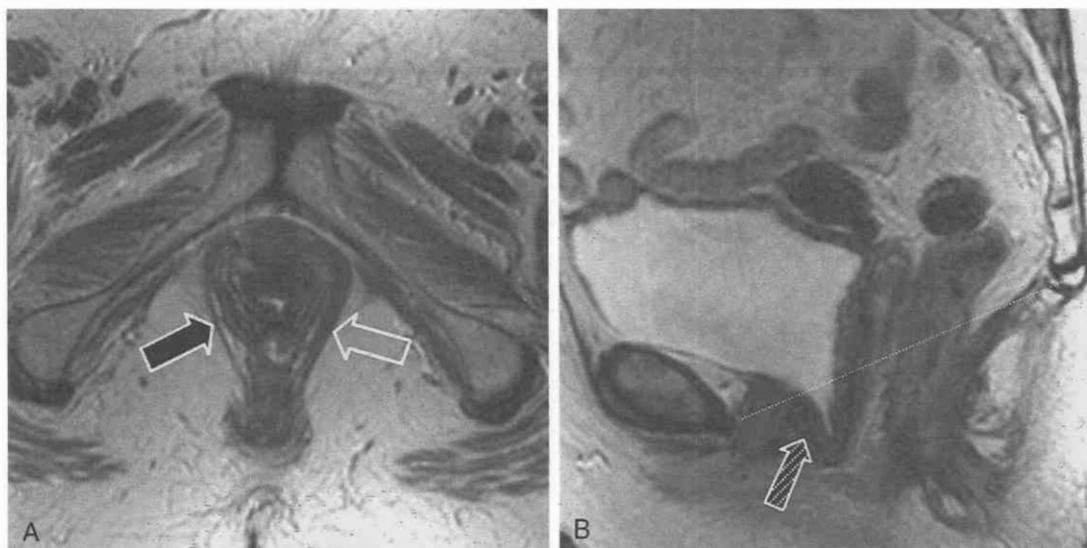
Pelvic floor relaxation in a 77-year-old woman with a history of obstetric trauma. A, T2-weighted, fast spin-echo image (TR = 4000, TE = 98) shows attenuation of the right puborectalis (black arrow) on the right compared to the left (open arrow). B, Sagittal T2-weighted image shows a cystocele (hatched arrow) projecting inferiorly below the pubococcygeal line (dotted line).
